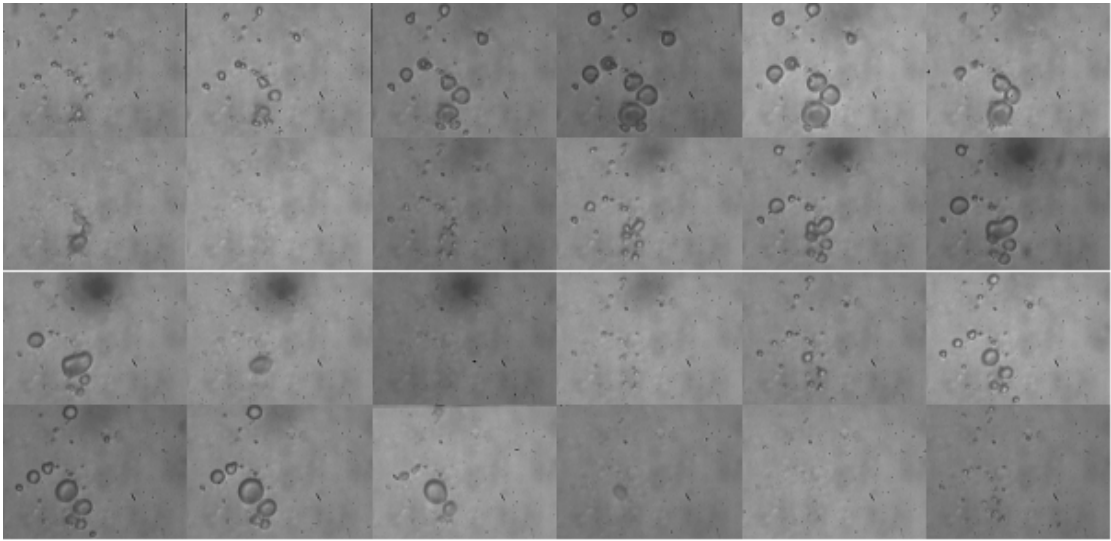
PLA microbubbles oscillating under ultrasound excitation.
